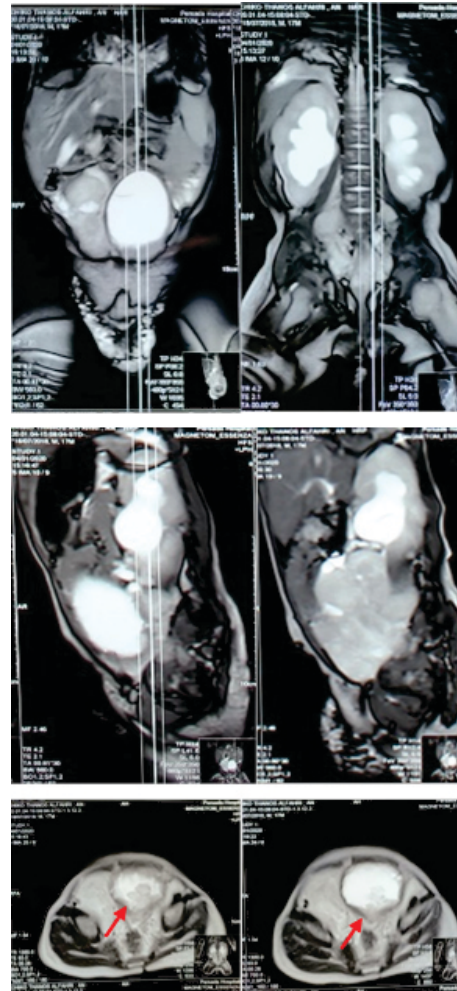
Magnetic resonance imaging (MRI) of the abdomen showed solid masses inferior to the bladder wall, bilateral severe hydronephrosis, lymphadenopathy, as well as multiple nodules in both lungs.
